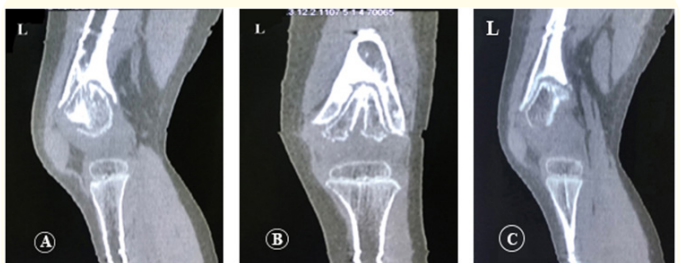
A-C. Injury of Condylar and Knee show on MRI.
